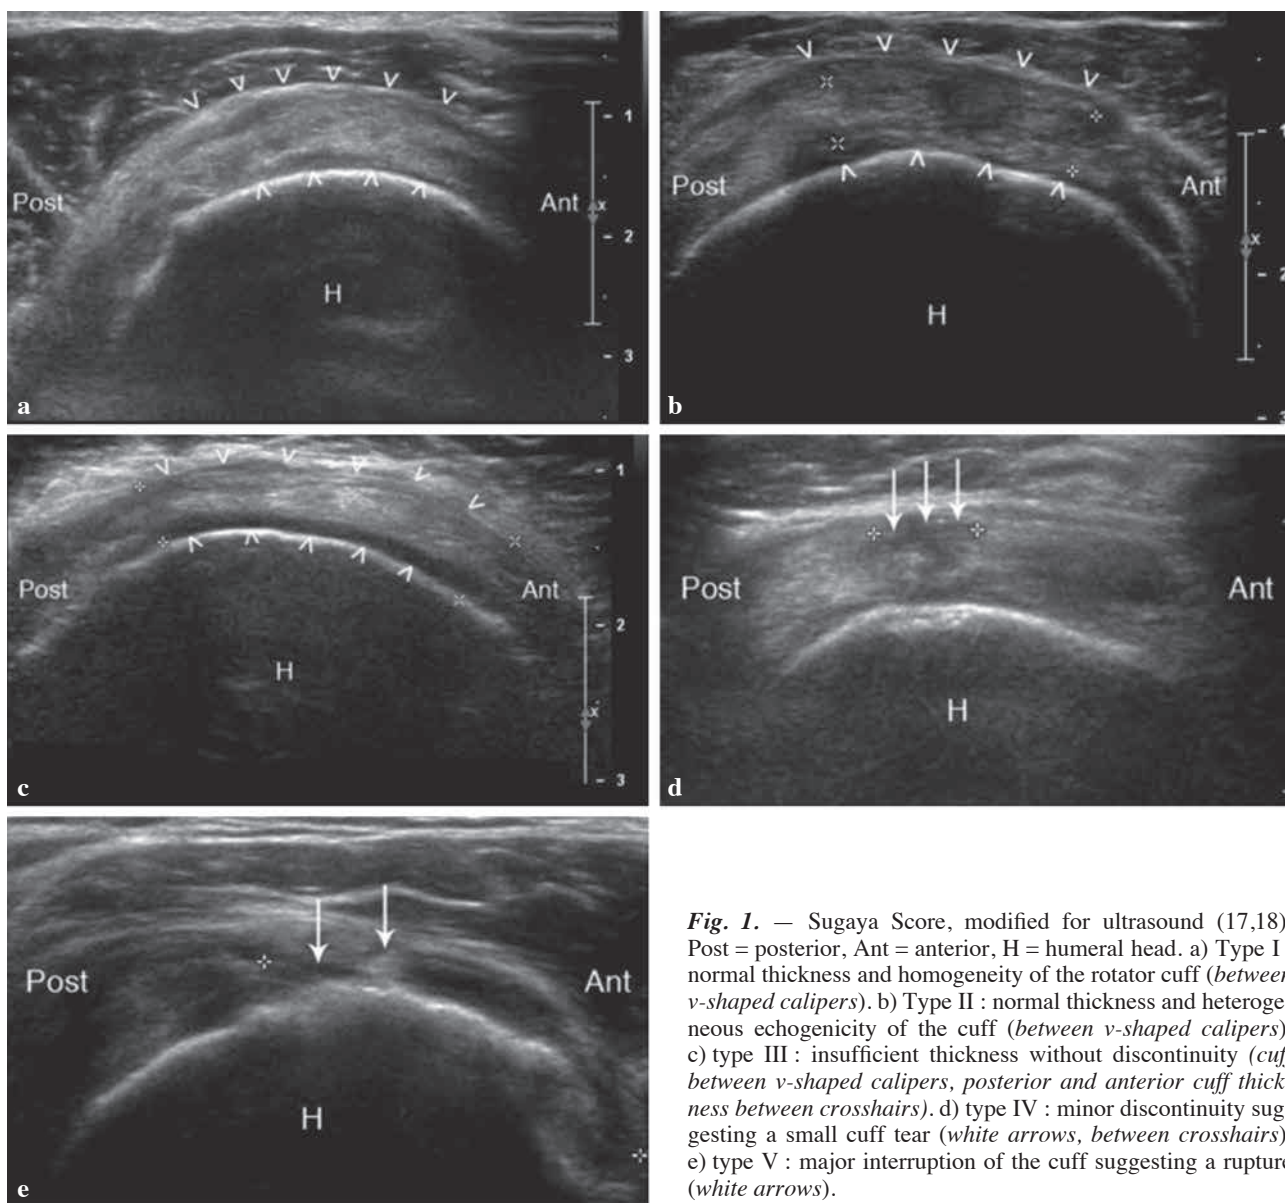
Sugaya Score, modified for ultrasound (17,18). Post = posterior, Ant = anterior, H = humeral head. a) Type I : normal thickness and homogeneity of the rotator cuff (between v-shaped calipers). b) Type II : normal thickness and heterogeneous echogenicity of the cuff (between v-shaped calipers). c) type III : insufficient thickness without discontinuity (cuff between v-shaped calipers, posterior and anterior cuff thickness between crosshairs). d) type IV : minor discontinuity suggesting a small cuff tear (white arrows, between crosshairs). e) type V : major interruption of the cuff suggesting a rupture (white arrows).
